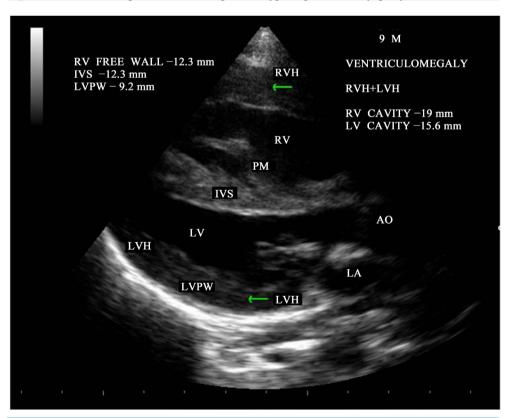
Parasternal long axis view showing dilated RV cavity.
